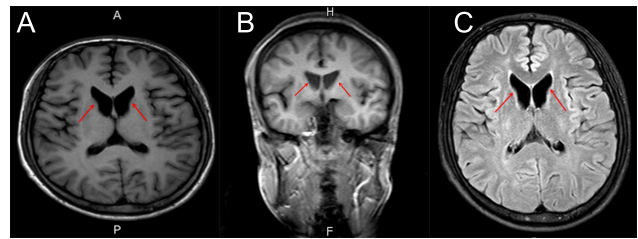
Magnetic resonance images showed bilateral atrophy of the head of caudate nucleus and anterior horn dilation of lateral ventricles (arrows). (A and B: T1 weighted image, C: Fluid attenuated inversion recovery image.)
